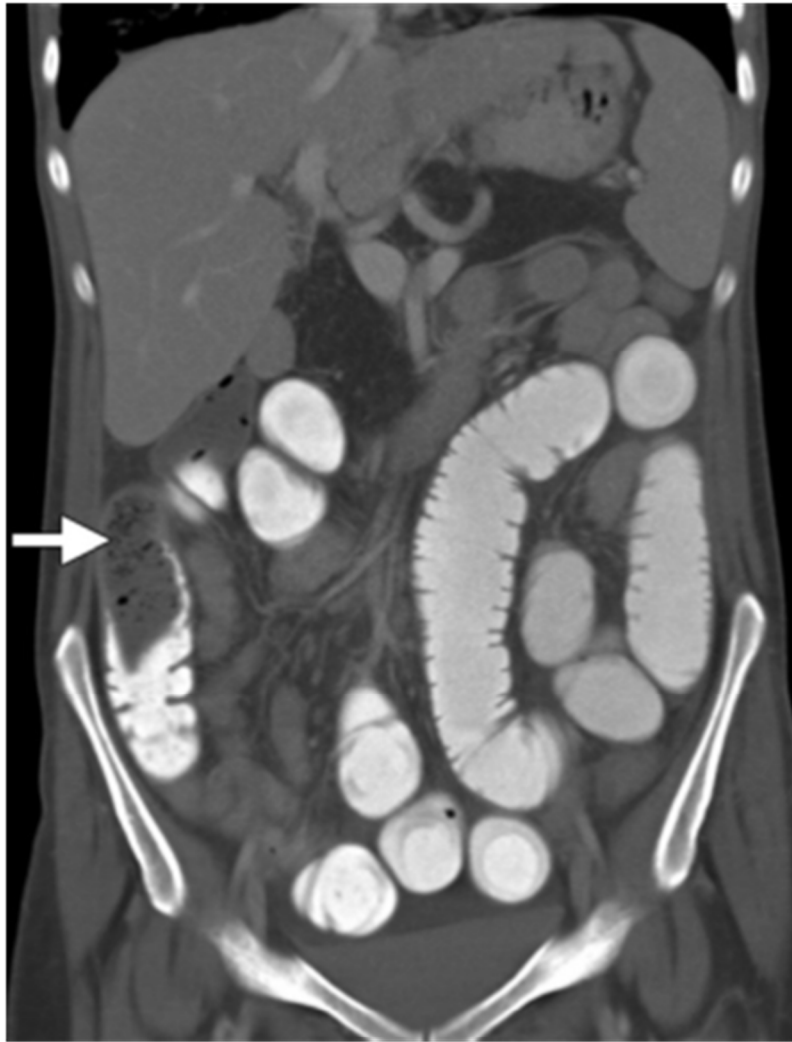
Distal intestinal obstruction syndrome (DIOS). CT scan in an adult patient with CF shows mucoid material (arrow) adherent to the small-bowel wall.
